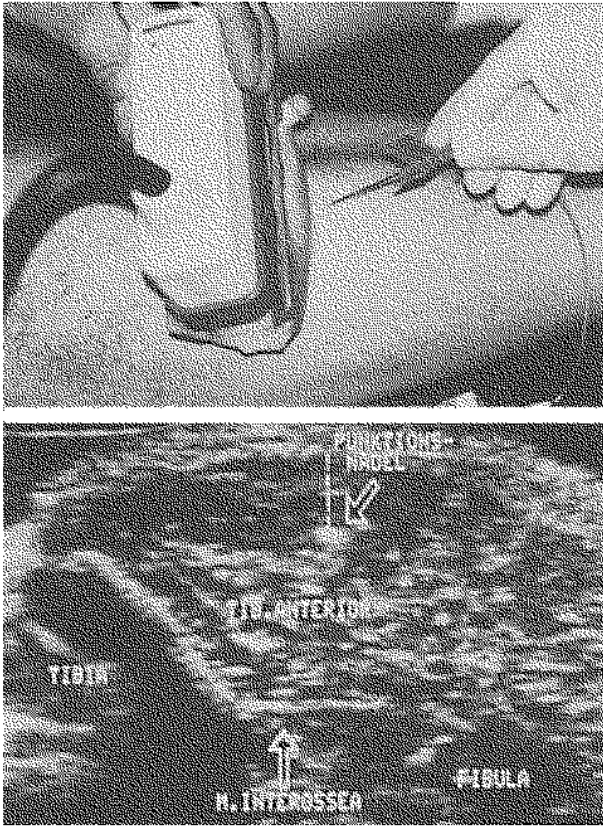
Placement of intramuscular catheter under ultrasound guidance.
